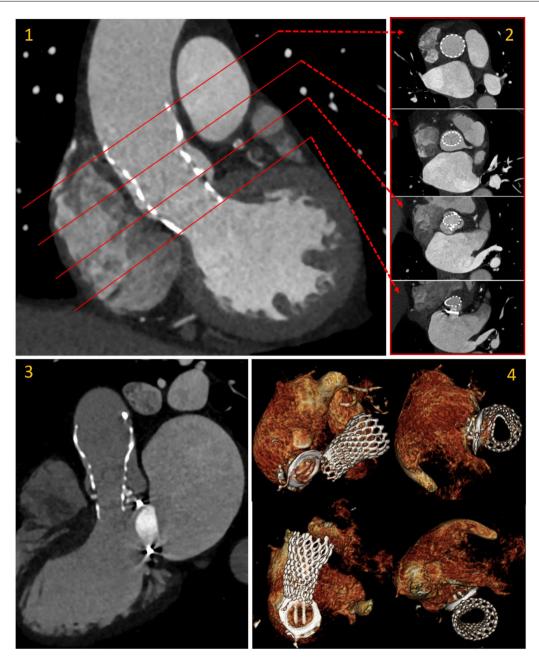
Post-procedural cardiac CT to access prosthesis morphology: modified coronal plane (1), short-axis (2), long-axis 3-chamber view (3) and volume rendering depicting the relation of TAVI prosthesis with the MMV with the restriction in expansion (elliptical shape) in the distal struts (4). This deformation is below the plane of the valve (CoraValve has a supraannular design).
